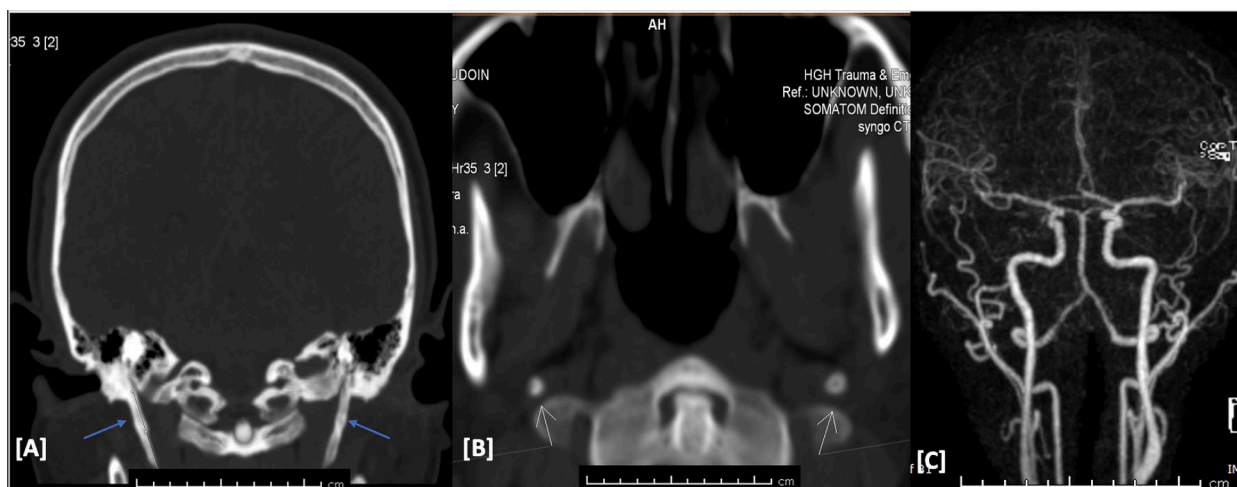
[A–C] CT head- Case two bilateral elongated styloid processes. [A and B] Axial and Coronal reconstructed MIP CT images in bone window setting showing thickened elongated styloid processes bilaterally (Blue and white arrow). [C] CT angiogram showing normal vasculature with no evidence of stenosis or dissection.
